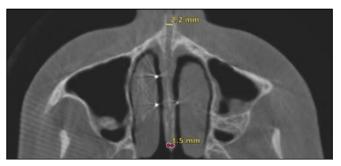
"WANS" and "WPNS" parameters: CBCT image in the axial plane.
